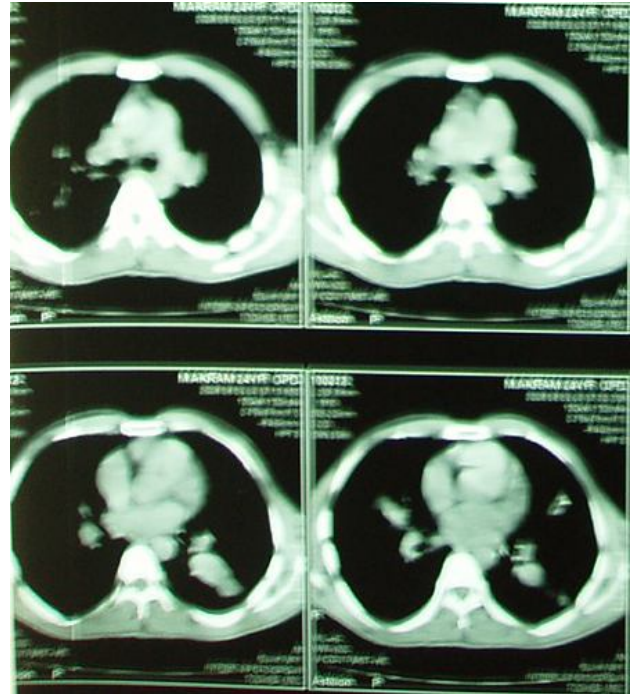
HRCT chest showing bilateral shadowing suggestive of mucoid impaction.
